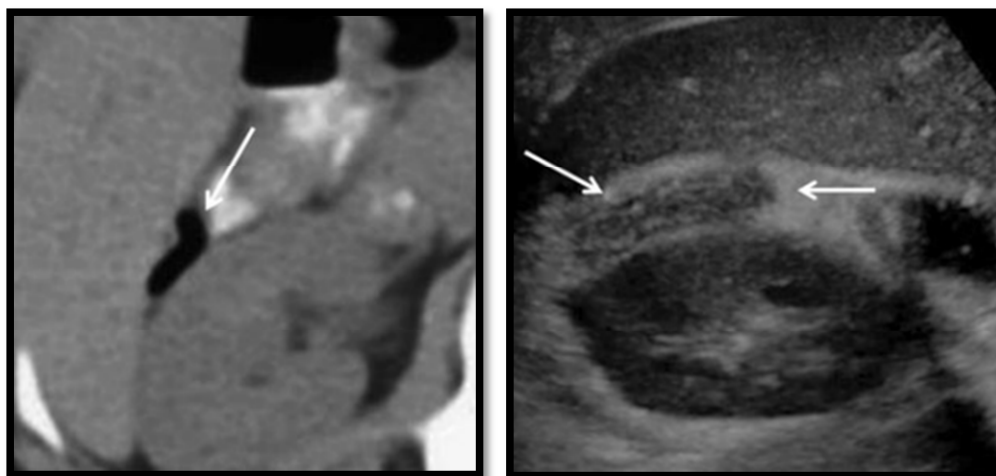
Unusual course of the appendix (arrows) in the upper abdomen into the hepatorenal fossa on CT and abdominal ultrasound
